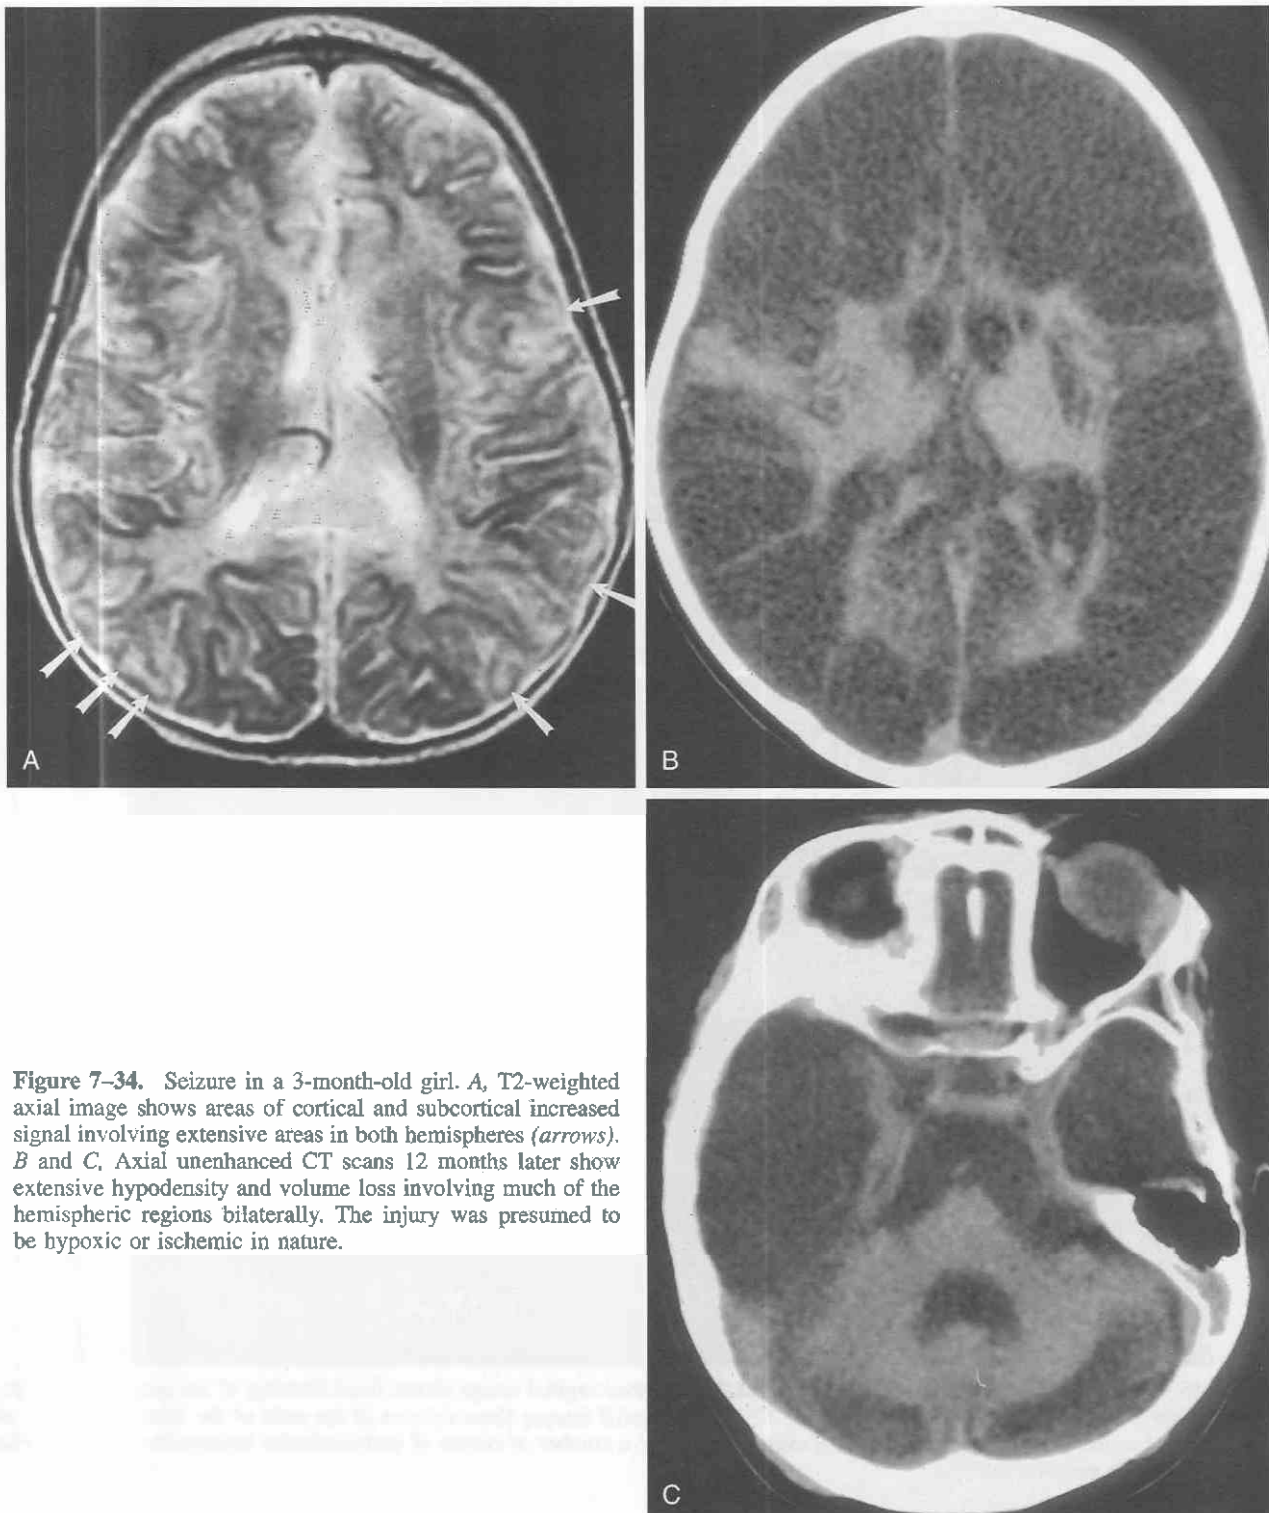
Seizure in a 3-month-old girl. *A*, T2-weighted axial image shows areas of cortical and subcortical increased signal involving extensive areas in both hemispheres (*arrows*). *B* and *C*, Axial unenhanced CT scans 12 months later show extensive hypodensity and volume loss involving much of the hemispheric regions bilaterally. The injury was presumed to be hypoxic or ischemic in nature.
